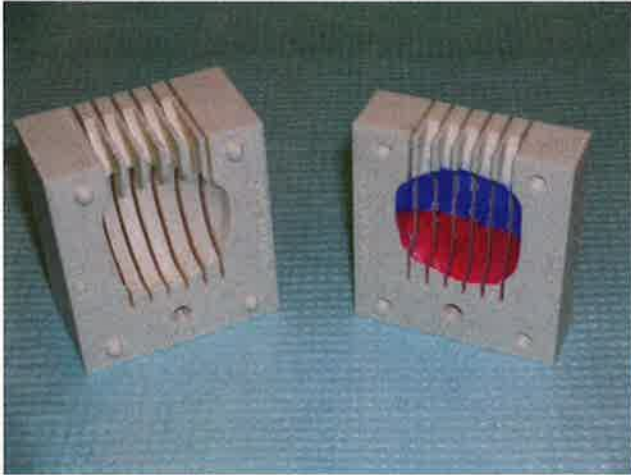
Customized MRI based prostatectomy mold
